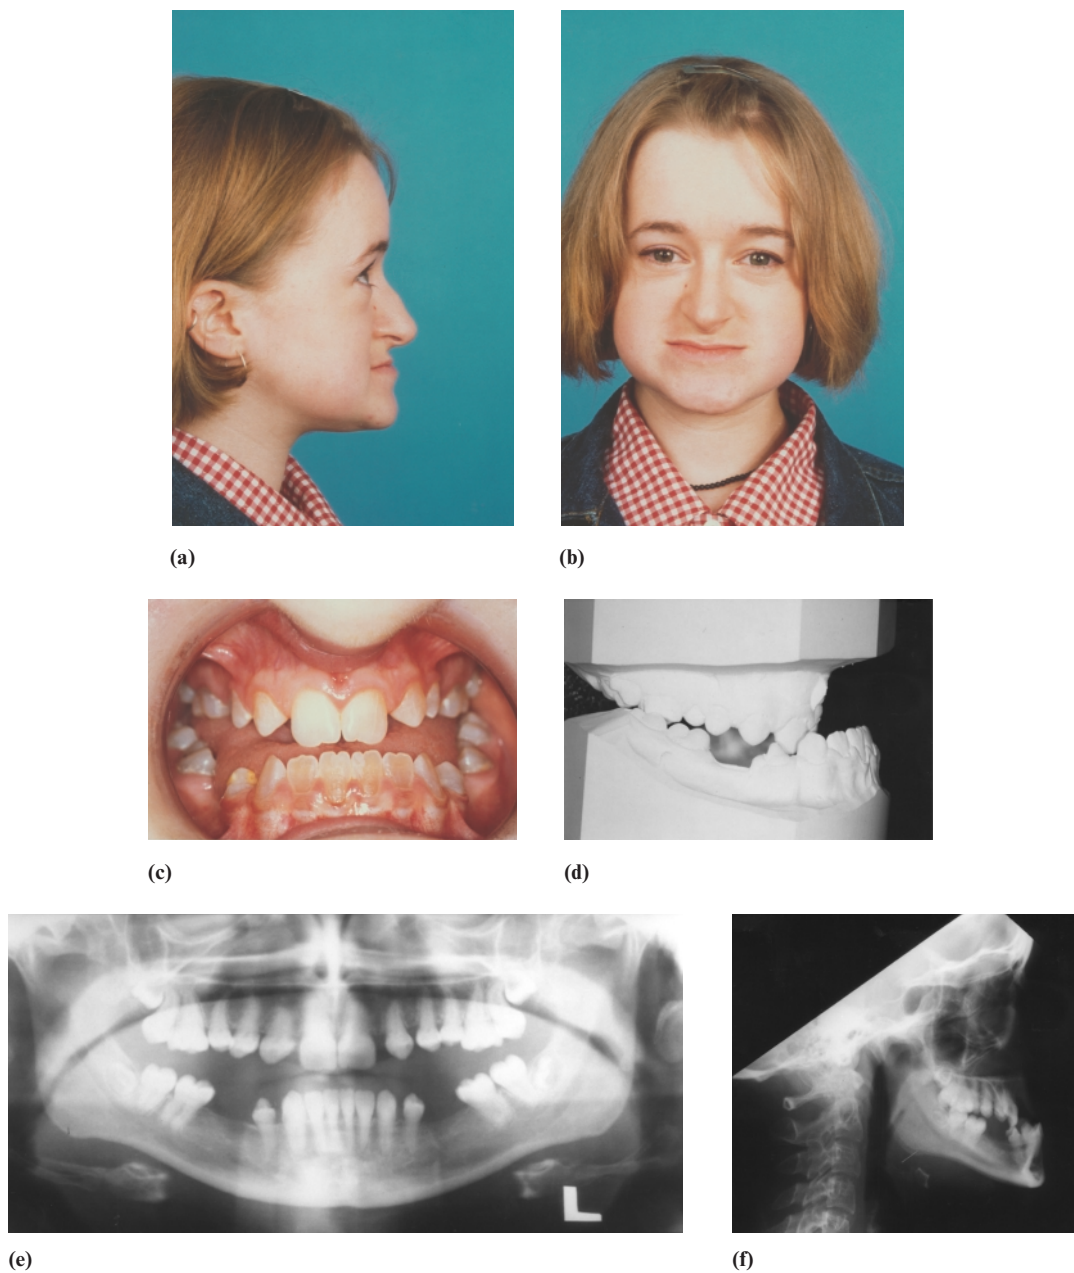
(a–f) Pre-treatment photographs, study models, orthopantomograph and lateral cephalograph. Intra-oral records and lateral cephalograph taken with teeth in occlusion.
